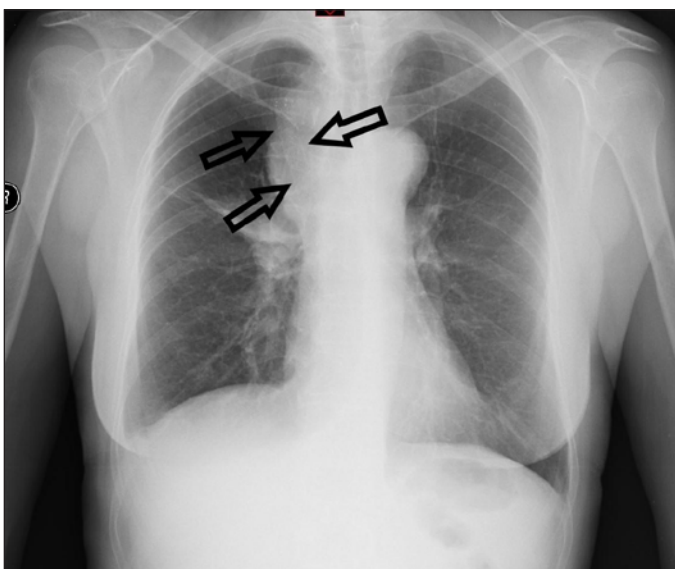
Chest X-ray: Intravascular stent in the projection of SVC
